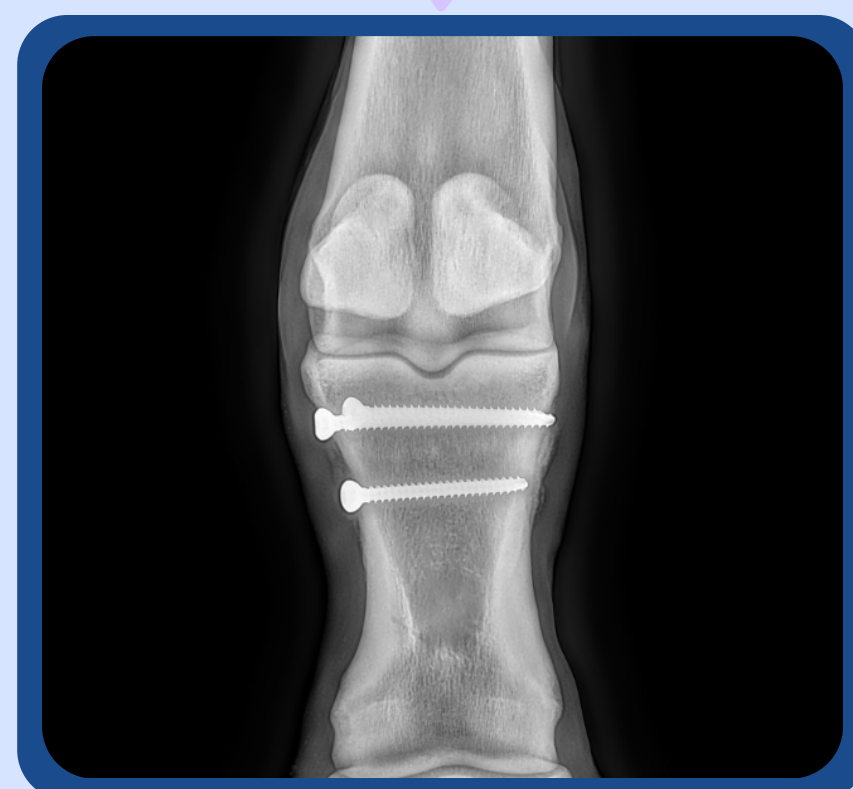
8 weeks post surgery repeat radiographs.
